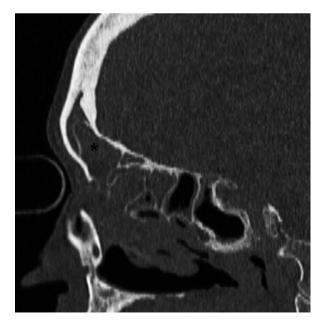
Sagittal CT image depicts a type III frontal cell (*asterisk*) extending into the frontal sinus proper. The cell was dissected with standard endoscopic frontal instrumentation
